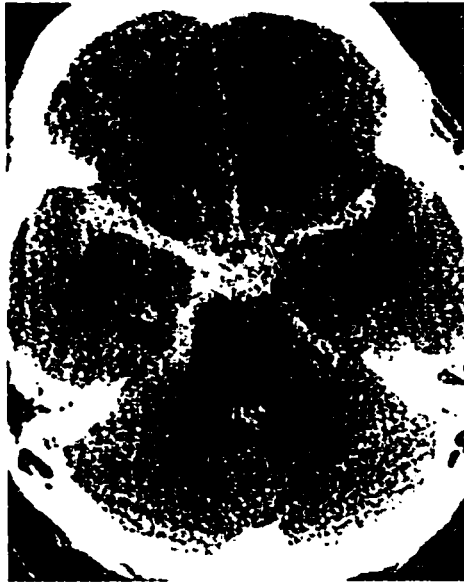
CT scan of the head showing subarachnoid hemorrhage (SAH)
